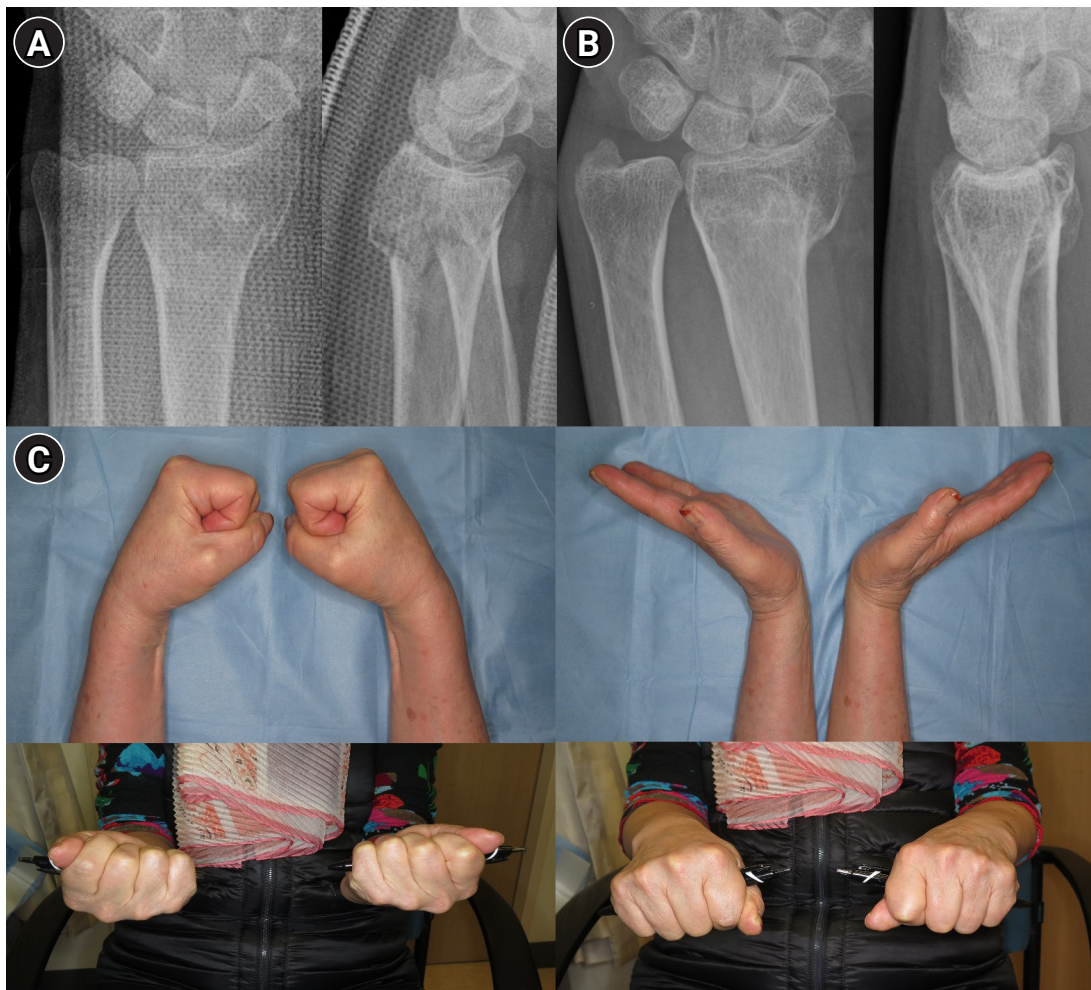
Outcome of conservative treatment in an older patient with a displaced distal radius fracture. Radiographs of a 71-year-old female patient. (A) Wrist anteroposterior and lateral radiographs obtained after initial reduction, demonstrating distal radius and ulnar styloid fractures with intraarticular comminution of the left wrist. Volar tilt and radial length were well restored after reduction. (B) Wrist radiograph obtained 1 year after trauma, showing radial shortening and dorsal tilt of the distal radius. (C) Range of motion of the left wrist was slightly decreased compared with the right side; however, the patient was able to perform daily activities without pain at one year after trauma.
